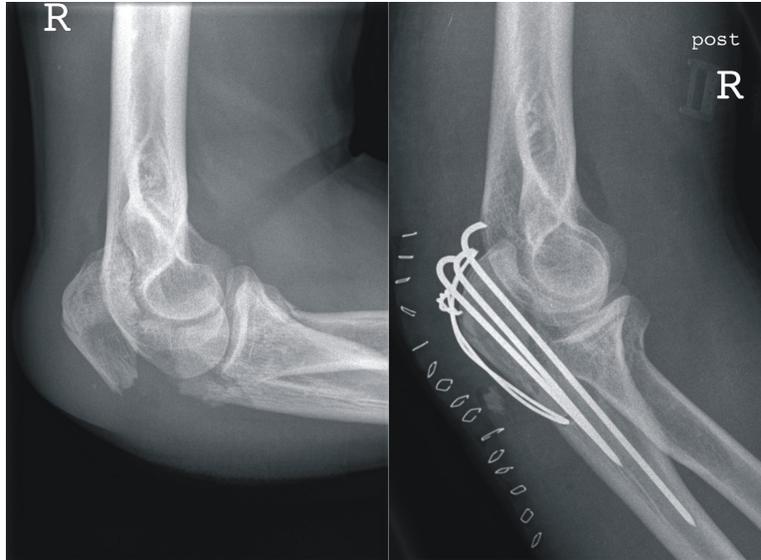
The upper part of the ulna, at the elbow is broken, as you can see in the X-ray at left. The x-ray at right was taken after a surgeon inserted pins into the joint to keep the two pieces of the ulna together. The two pieces of bone were reattached with metal pins. The line of staples is closing the skin wound. (21)
